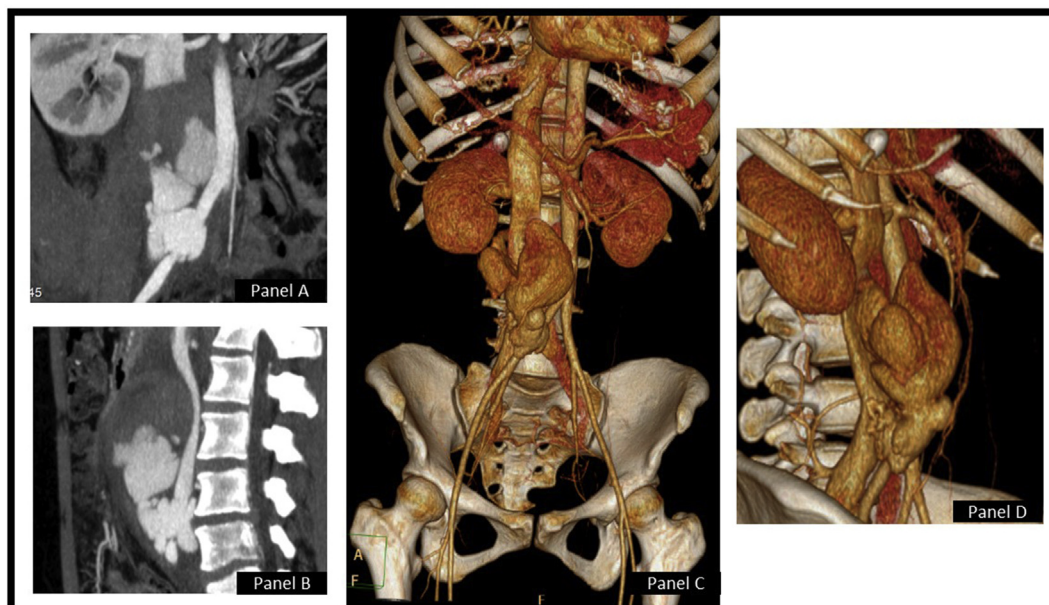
Computed tomography angiography revealed (A) complete transection of the right common iliac artery and vein, with (A–C) active haemorrhage, and a large pseudoaneurysm and (A, B, D) an arteriovenous fistula between the right iliac vein and the pseudoaneurysm.
